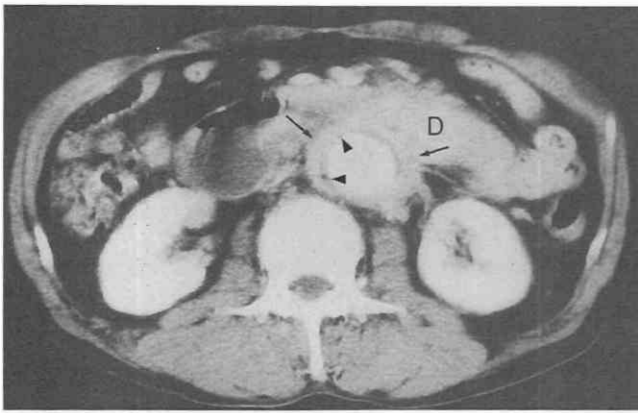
Primary aortoduodenal fistula in a patient with an aortic aneurysm. CT scan shows periaortic fibrosis (arrows) with subtle gas bubbles (arrowheads) in the periaortic region. The duodenal wall (D) adjacent to the aortic aneurysm is thickened, causing low-grade duodenal obstruction.
